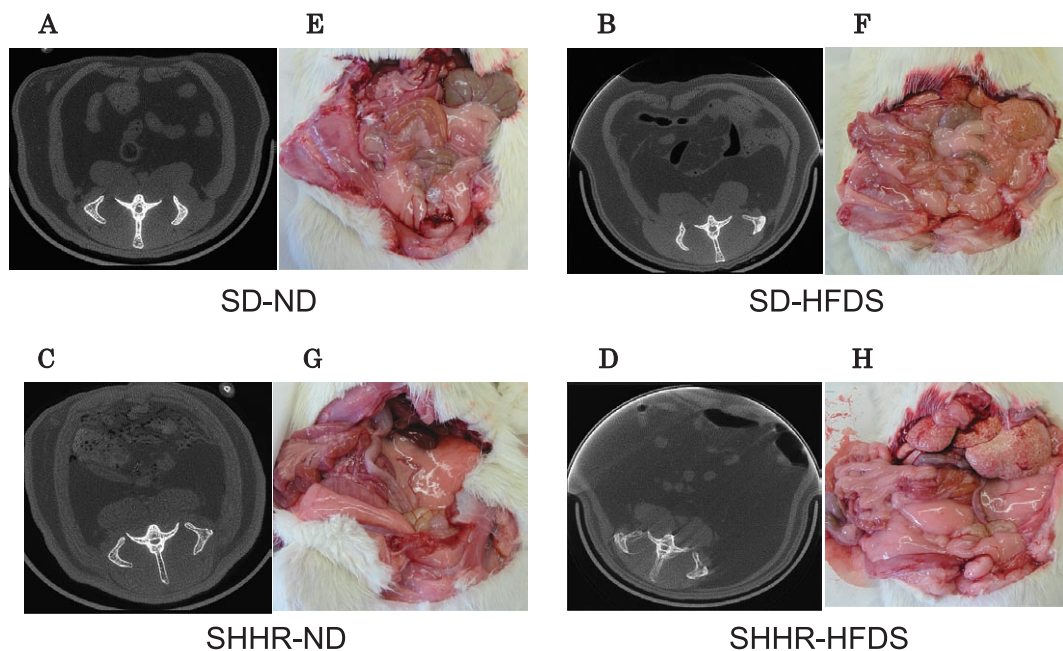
CT images of abdominal sections and VisF images after abdominal dissection in SD-ND (A, E), SD-HFDS (B, F), SHHR-ND (C, G) and SHHR-HFDS (E, H) at 11 months of age.
